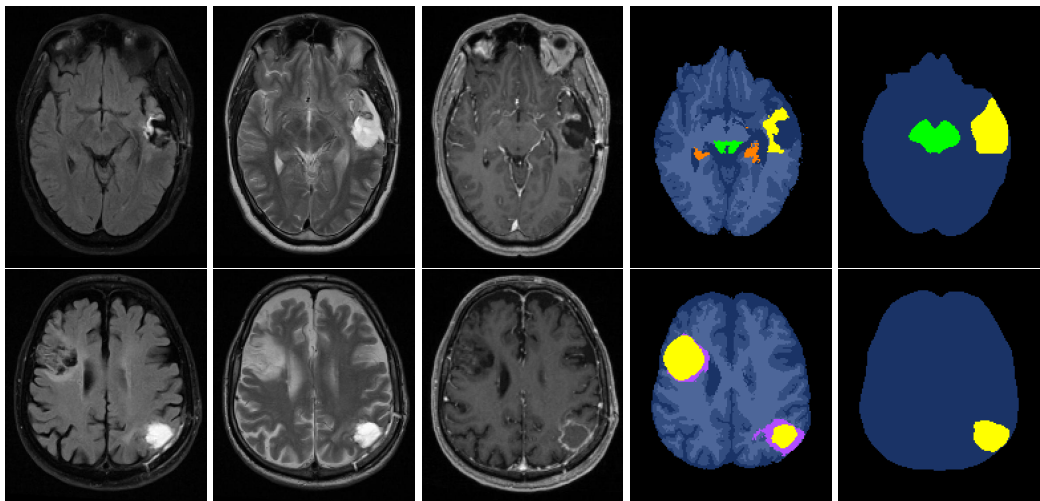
Slices of two failed subject. From left to right: MR-contrasts: FLAIR, T2 and T1c; segmentation by method; and manual segmentation. GTV is in yellow, brainstem is in green, hippocampus is in orange, edema is in lilac, non-brain tissue is in black and healthy superstructures are in shades of blue.
